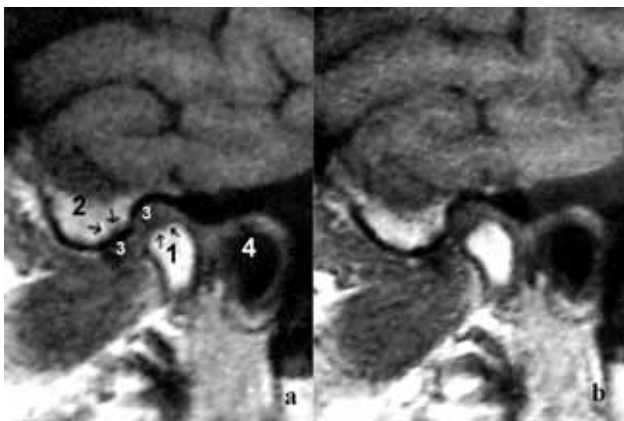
MRI of the right TMJ in closed mouth position prior to splint treatment (a) and the same MRI with the applied stabilization splint (b) Note: degenerative changes with subchondral sclerosis (arrows) (1 condyle, 2 articular eminence, 3 articular disc, 4 external auditory meatus)
